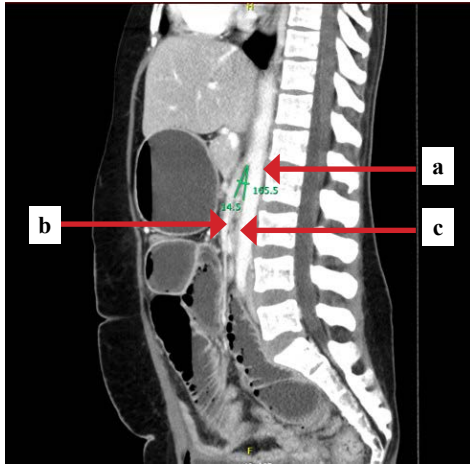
Sagittal view of a CT of the abdomen demonstrating an aortomesenteric angle of 14.5°; a) aorta, b) SMA, c) duodenum
